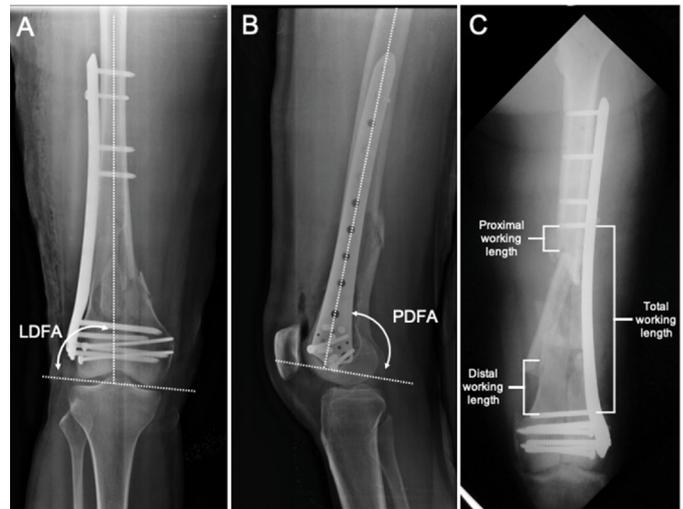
Radiographic measurements. - A- Lateral distal femoral angle (LDFA), B- Posterior distal femoral angle (PDFA), C- Total working length, proximal and distal working length.
